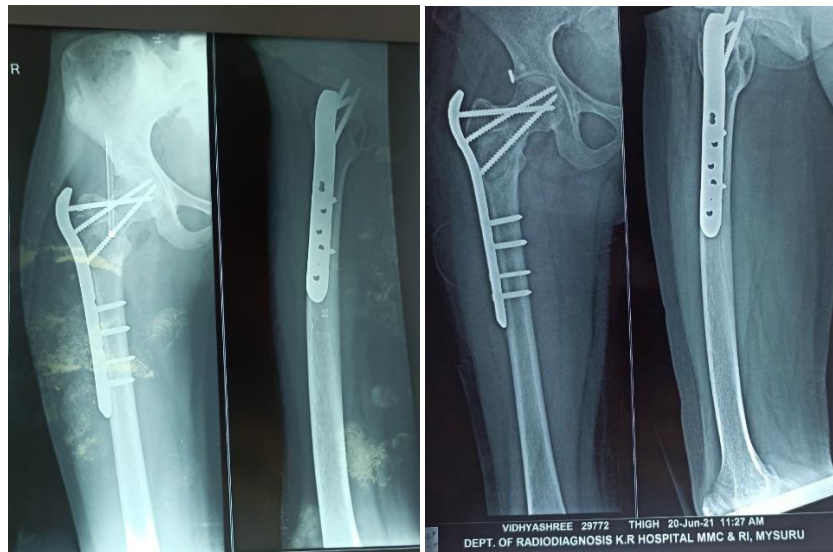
Follow-up x-rays
